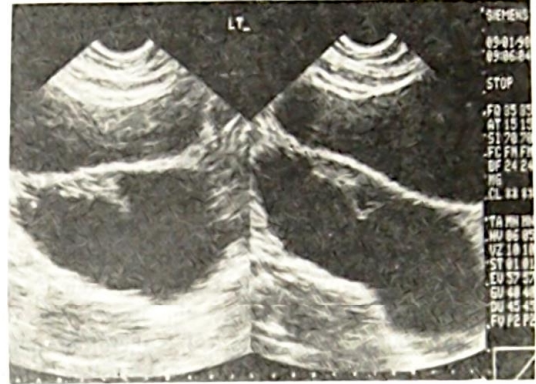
(Case 7): Ultrasonic scan showing a well-defined anechoic mass with inner nodule on its anterior wall.
